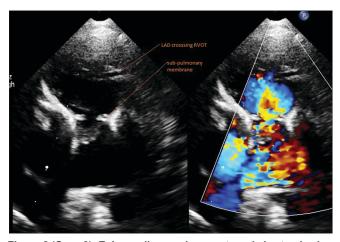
(Case 3): Echocardiogram in parasternal short-axis view with color comparing image showing discrete subpulmonary membrane. Turbulence in color flow starts at the level of subpulmonary membrane
